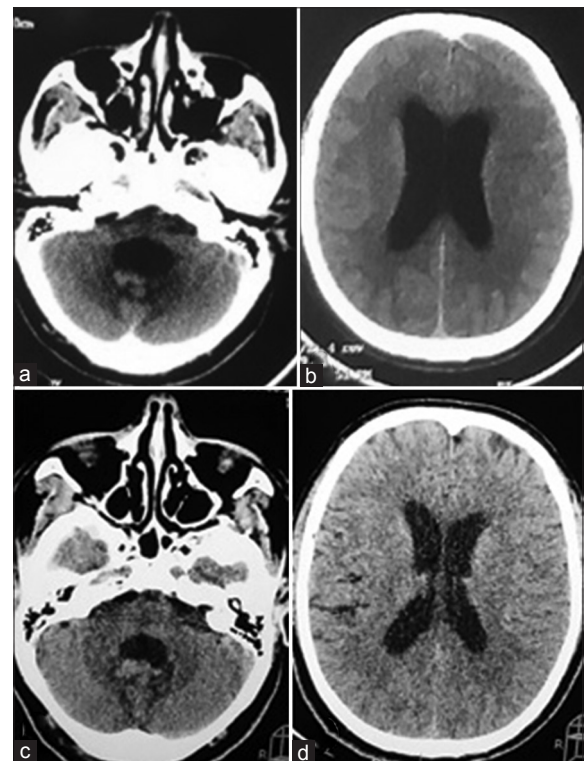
(a and b) Preoperative CT scan with tetraventricular dilatation. (c and d) Postoperative CT scan hydrocephalus resolved
